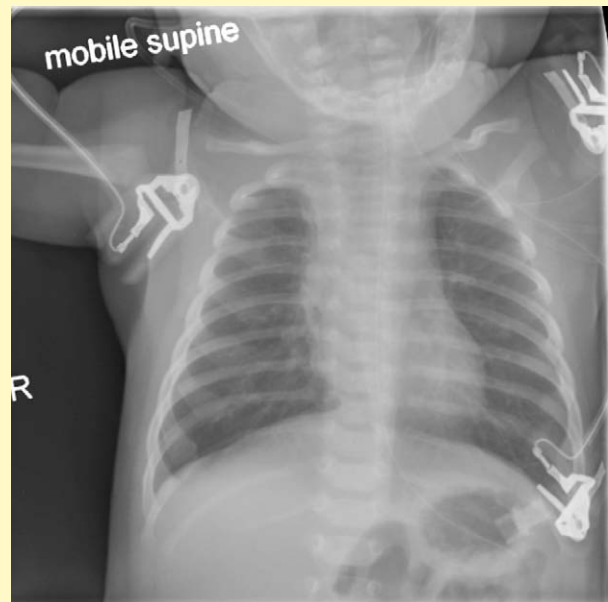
Chest X-ray of patient.
